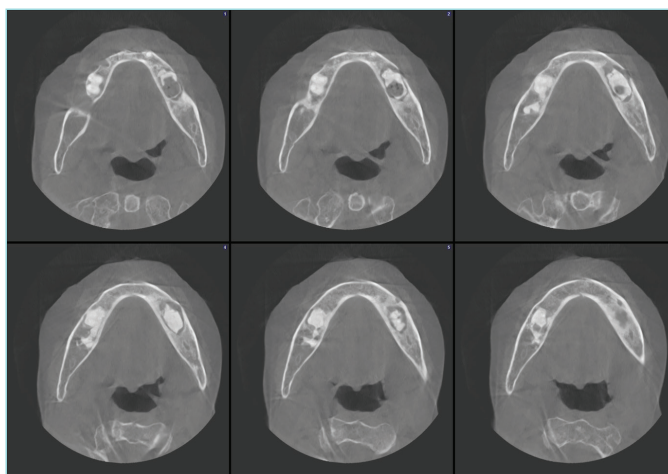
Axial view of the case in the CBCT: The imaging shows well-defined lesions in the right and left mandibular posterior regions, causing resorption and lytic areas in the mandibular bone, with well-defined radiopaque areas within.
